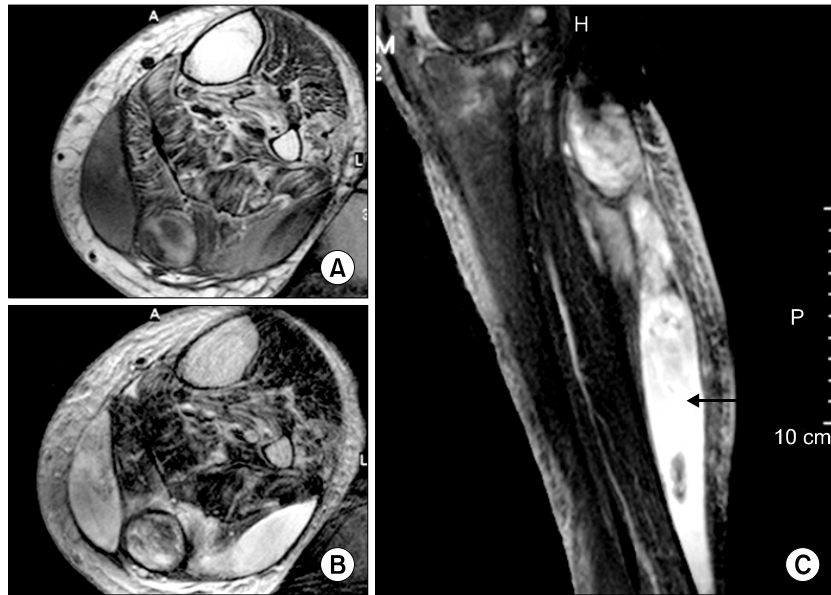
A-72-year old woman with rheumatoid arthritis and ruptured and dissected baker cyst. Axial T1-weighted MR image (A), T2-weighted image (B), and coronal sagittal fat-suppressed image (C) show ruptured and dissected baker cyst, appearing with heterogeneous high signal intensity due to internal synovial proliferation and hemorrhage within the gastrocnemius muscle and space between the superficial fascia and the both head of the gastrocnemius muscle (arrow).
